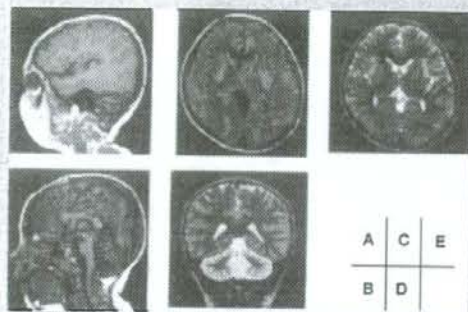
A magnetic resonance image of the patient's brain at the age of 4 years. The sagittal (B) and the coronal (D) sections reveal cerebellar atrophy. E: The transverse section of a T2-weighted image shows atrophy of the globus pallidus. A, C: No significant cortical change was noted in cerebral gray or white matter.
